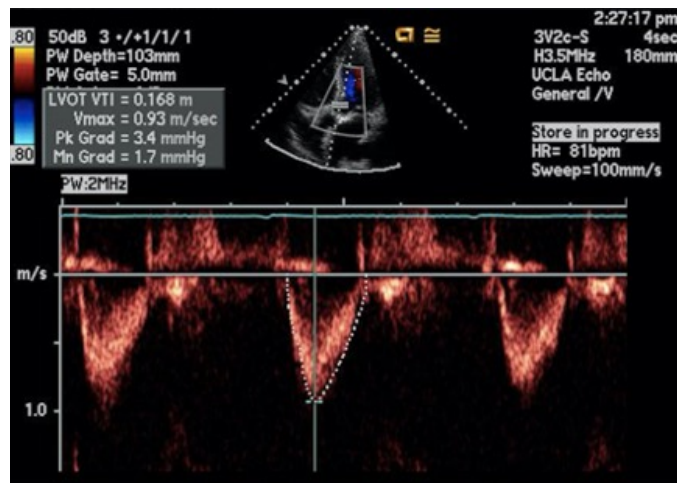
Repeat TTE at One Month of Anticoagulation: Apical five-chamber view reveals no improvement in aortic valve functioning.
